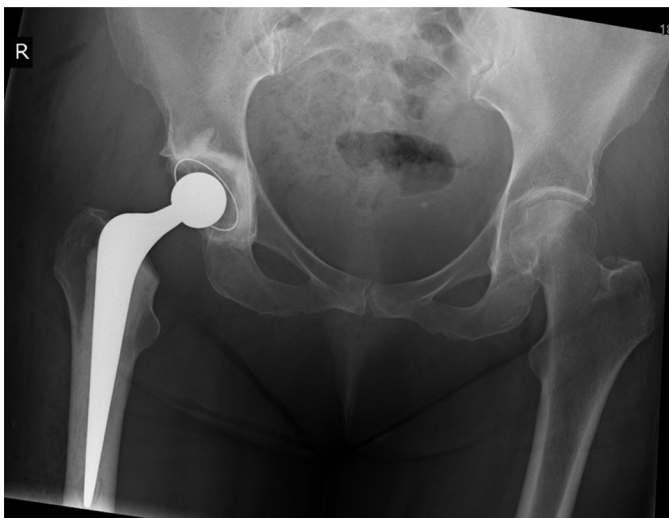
Post-operative radiograph with satisfactory position of the prosthesis.
